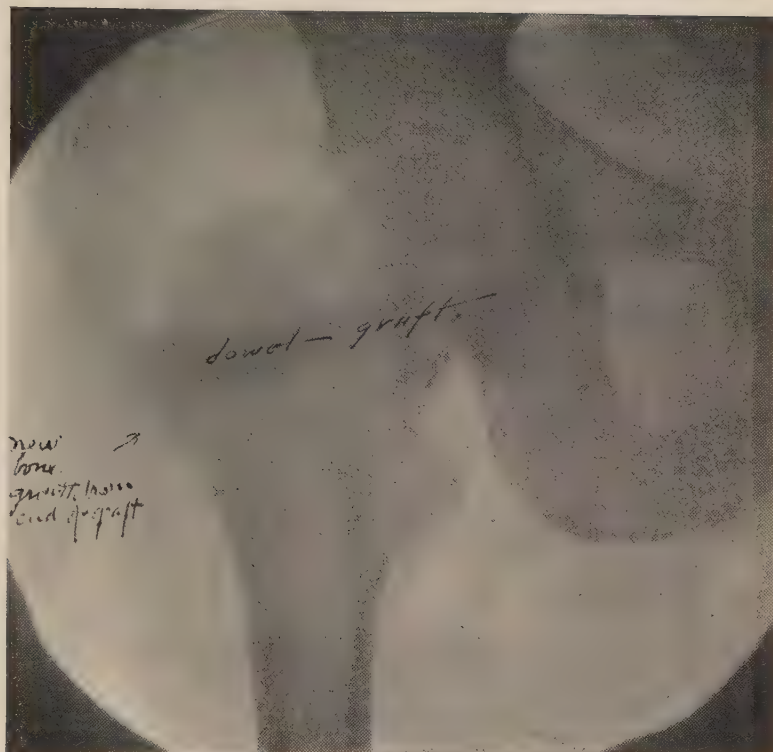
X-ray taken five weeks after operation. Case of ununited fracture of neck of femur of three and one-half months' duration, in woman of sixty years. In five weeks there was firm union. The most interesting feature about this x-ray is the large growth of bone from the external end of the graft itself, demonstrating the early bone-forming ability of the bone graft. After freshening the ends of the fragments, a hole the size of one's forefinger in diameter was made by a motor-driven drill through the outside of trochanter, through neck and head. Into this a dowel-shaped graft from the patient's tibia was driven with considerable force into place.
